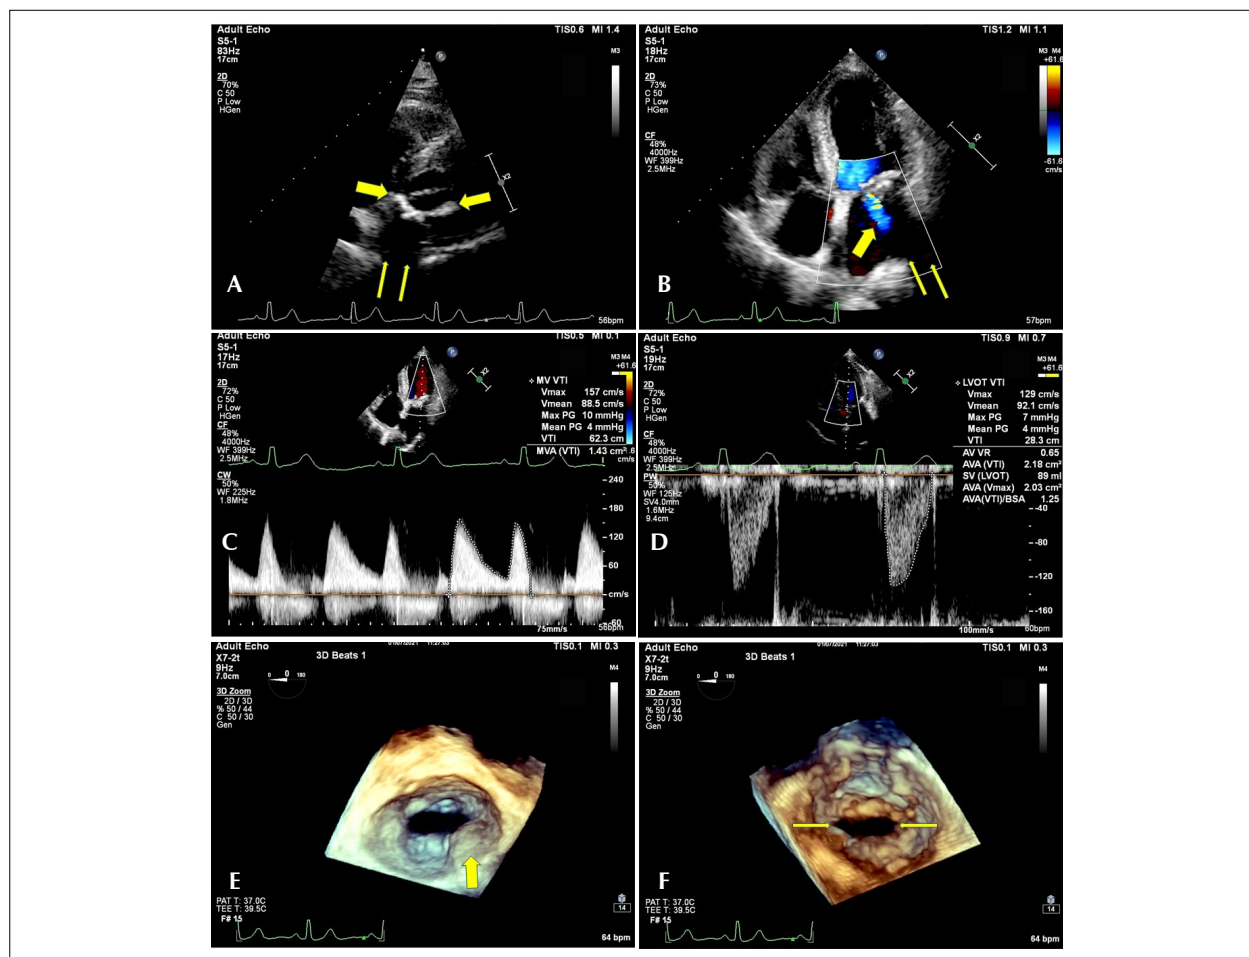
Patient with mitral annular calcification (MAC) and a double valve lesion. A. The parasternal short-axis plane at the level of the mitral valve showing calcification of the posterior valve annulus (thick arrow) with formation of a posterior acoustic shadow (thin arrow). B. The apical four-chamber plane with color Doppler showing mitral insufficiency (thick arrow) and the formation of posterior acoustic shadow (thin arrow). C. The time-velocity integral obtained with continuous-wave Doppler of the mitral inflow. D. The time-velocity integral obtained with pulsed-wave Doppler of the LV outflow tract. E. Three-dimensional (3D) transesophageal echocardiogram from the left atrium perspective showing asymmetric MAC distribution (thick arrow). F. The 3D transesophageal echocardiogram from the LV perspective showing a slightly reduced valve opening without commissural involvement (thin arrows).
